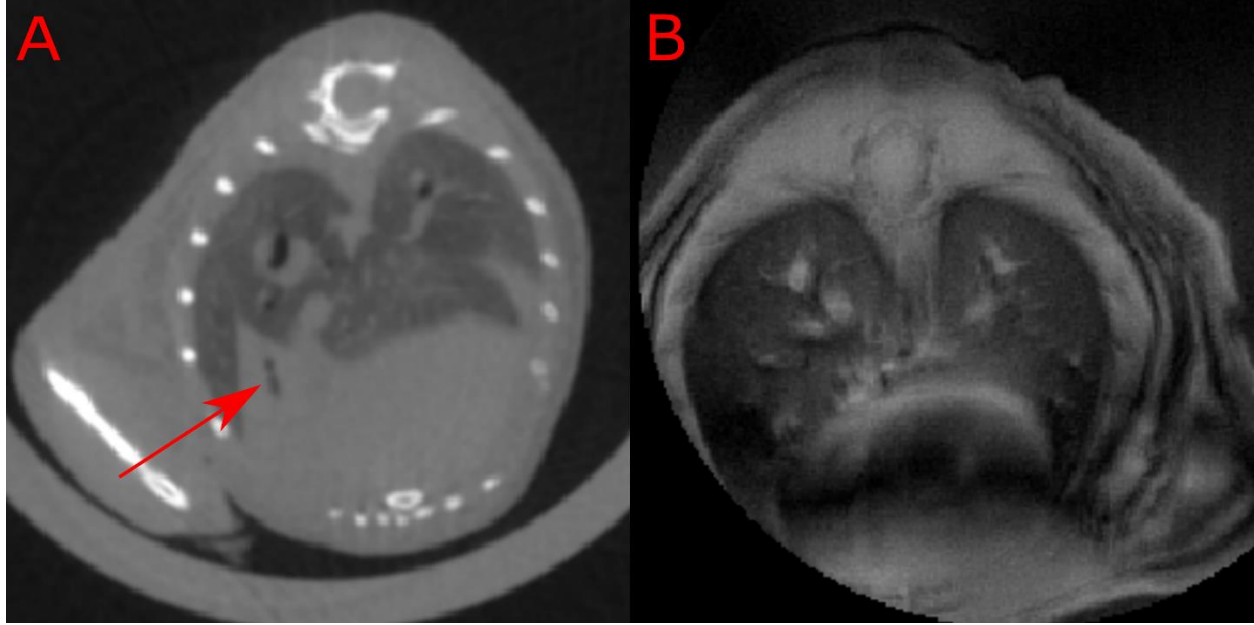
Comparison of subject 180's CT (A) and MR (B) images taken at 8 weeks. Noticeable RIPF is seen in the CT image especially near the heart (red arrow), but the MR image fails to produce any noticeable pathology in comparison.
